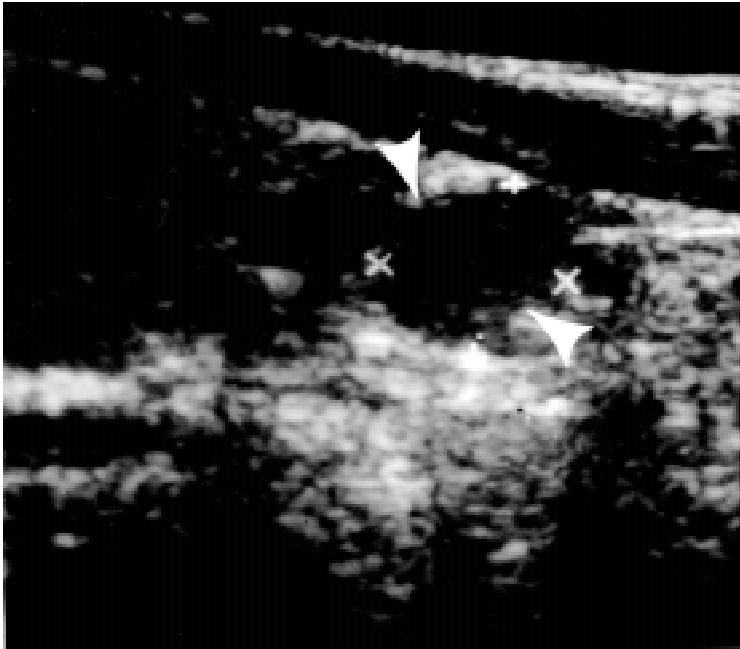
Ultrasound of the neck. Parathyroid adenoma is the echogenic lesion relative to the thyroid as indicated at white arrows.
